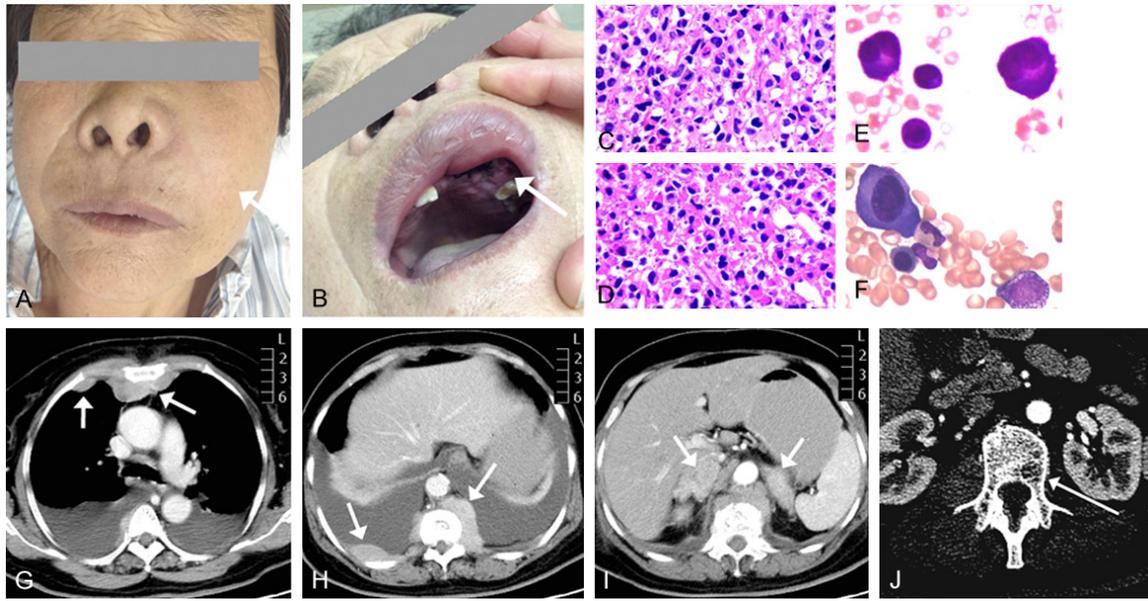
Clinical manifestations of the neoplasm. Patient pictures showing the left cheek swelling (A) and gingival mass (B). Pathology analysis revealed plasmacytoma in gingival mass (C) and post-sternal mass (D). Plasmacytoma cells were detected in pleural effusion (E) and bone marrow (F). CT scans showing pleural effusion (G, H) and abnormal soft tissue density mass (white arrow, G-I) and a typical osteolytic lesion in vertebra (J).
